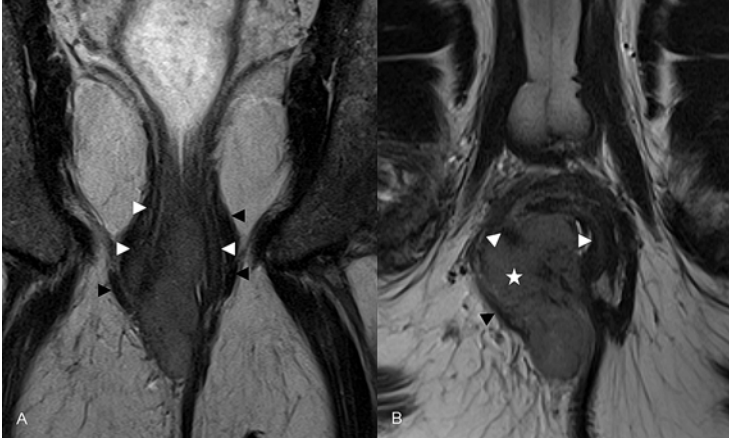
Anal carcinoma. Coronal (a) and axial (b) T2-weighted images through the anus showing an intermediate intensity T4N0 anal carcinoma involving the IAS (*white arrow heads*) on the right and extending into the expanded intersphincteric space (*white star*) and through the posterior, inferior aspect of the EAS (*black arrowheads*) into the gluteal fat and finally through the skin (not shown)
